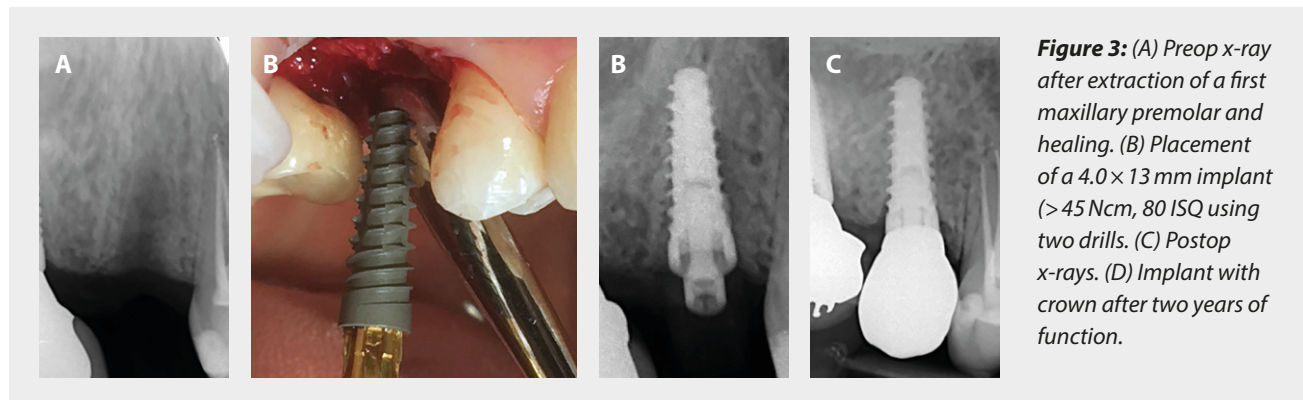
(A) Preop x-ray after extraction of a first maxillary premolar and healing. (B) Placement of a 4.0 x 13 mm implant (> 45 Ncm, 80 ISQ using two drills). (C) Postop x-rays. (D) Implant with crown after two years of function.
